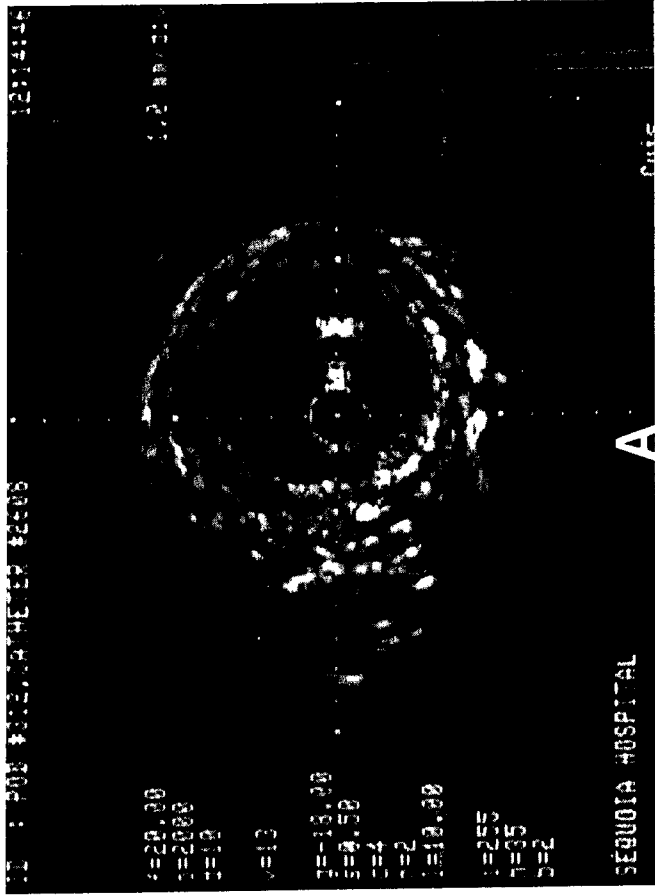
Intravascular ultrasonic image showing the characteristic three-layer appearance of a normal artery. Mild plaque and calcification can be observed at 7 o'clock. (Photo courtesy of Cardiovascular Imaging Systems, Inc.)
